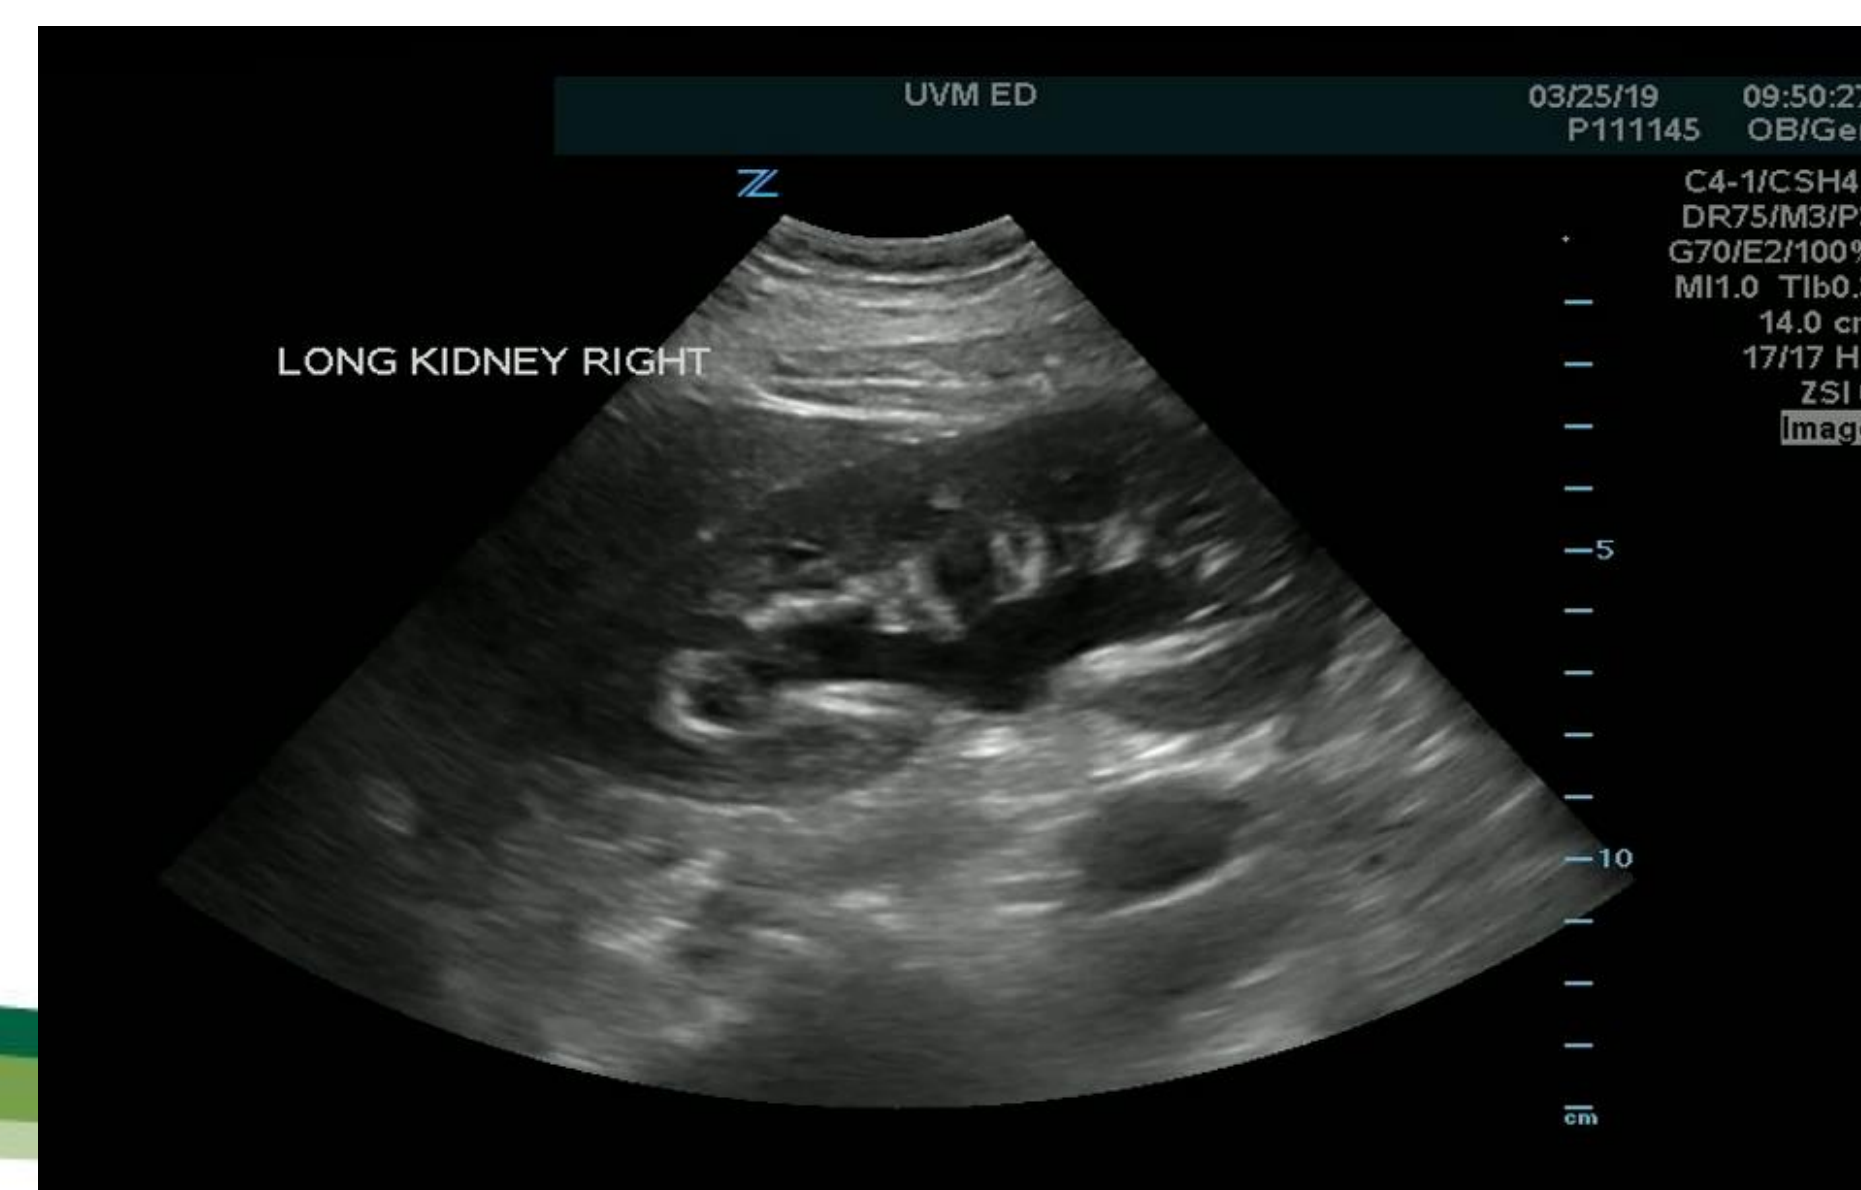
Ultrasound of right kidney showing moderate hydronephrosis.
